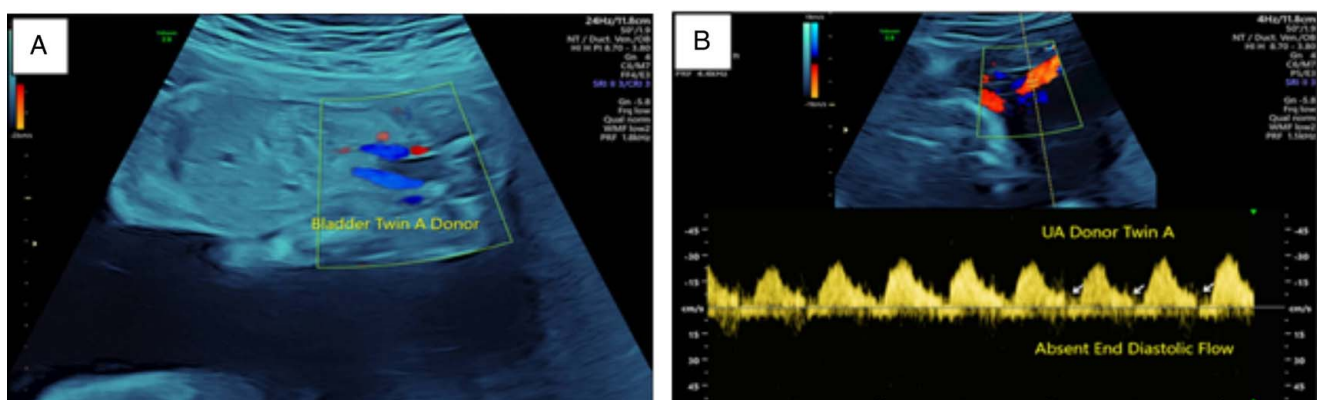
A. Bladder filling in the donor twin was observed. B. Absent end-diastolic flow (AEDF) shown by Doppler umbilical artery velocimetry.
